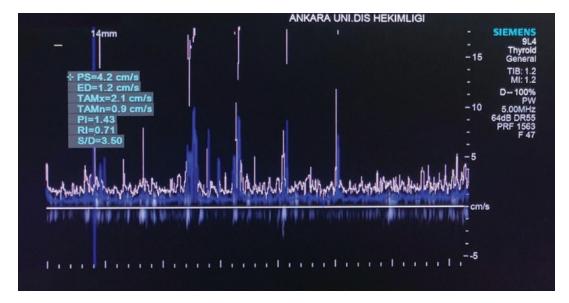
Example of Spectral Doppler examination with measurements of blood velocity and indices
